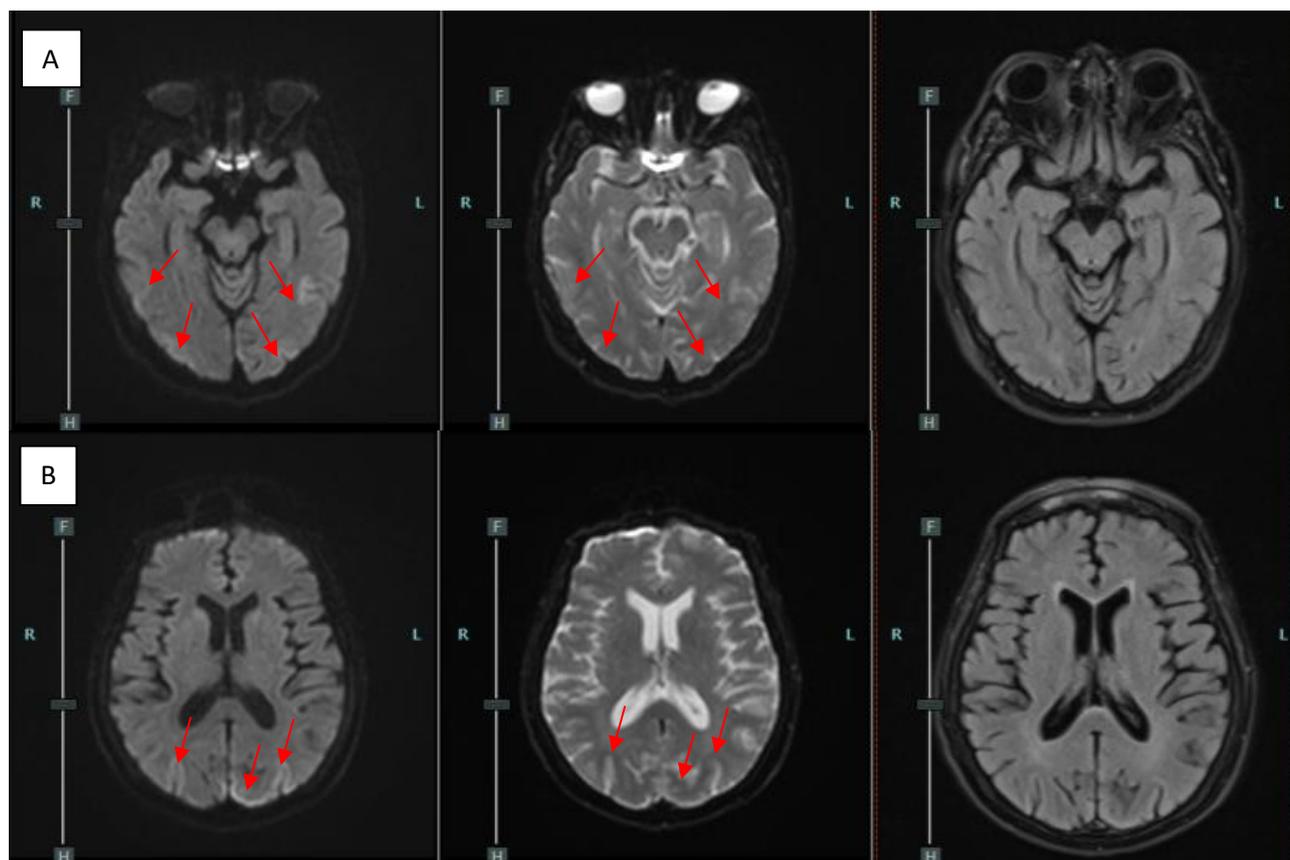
The figure presents axial magnetic resonance imaging (MRI) images obtained at different levels from the occipital regions using various sequences. Diffusion-weighted imaging (DWI) reveals restricted diffusion in the affected areas bilaterally. Corresponding apparent diffusion coefficient (ADC) maps show these regions as hypointense to isointense. T2-weighted fluid-attenuated inversion recovery (FLAIR) sequences demonstrate predominantly isointense lesions with limited focal areas of hyperintensity
